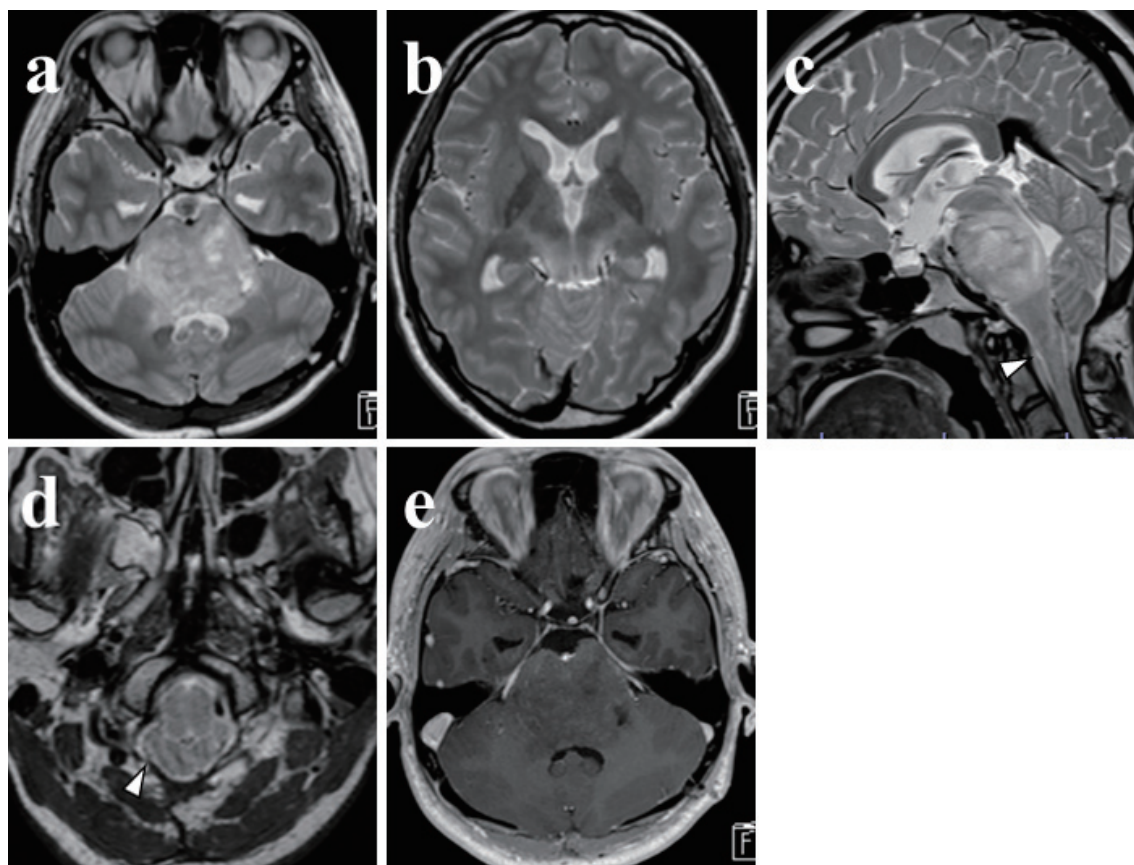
MRI follow-up post-surgery. a, b: Postoperative T2-weighted image indicating improvement of hydrocephalus and periventricular edema. c, d: Images indicating that a space and a flow void of the CSF at the foramen magnum were visualized (white arrowhead). e: T1-weighted gadolinium (Gd)-enhanced MRI showing no apparent contrast enhancement in the tumor.
